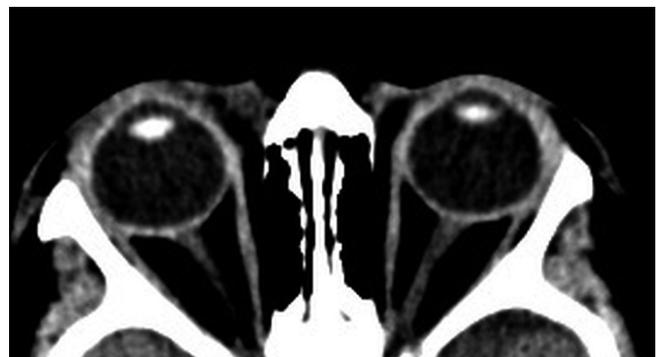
CT finding of the patient at one year after 6 months of treatment with metoprolol
